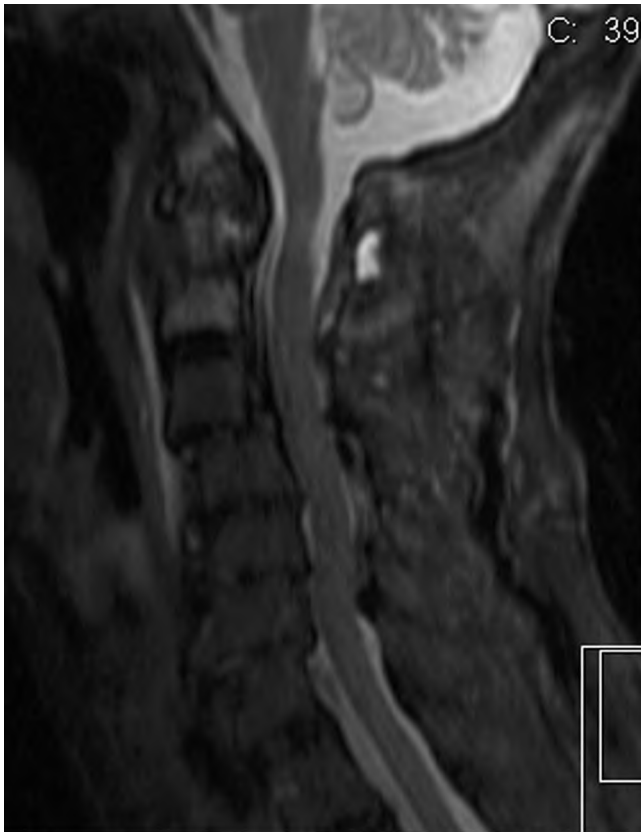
Sagittal T2-weighted magnetic resonance image demonstrating a heterogeneously hyperintense lesion infiltrating the atlas and dens.
